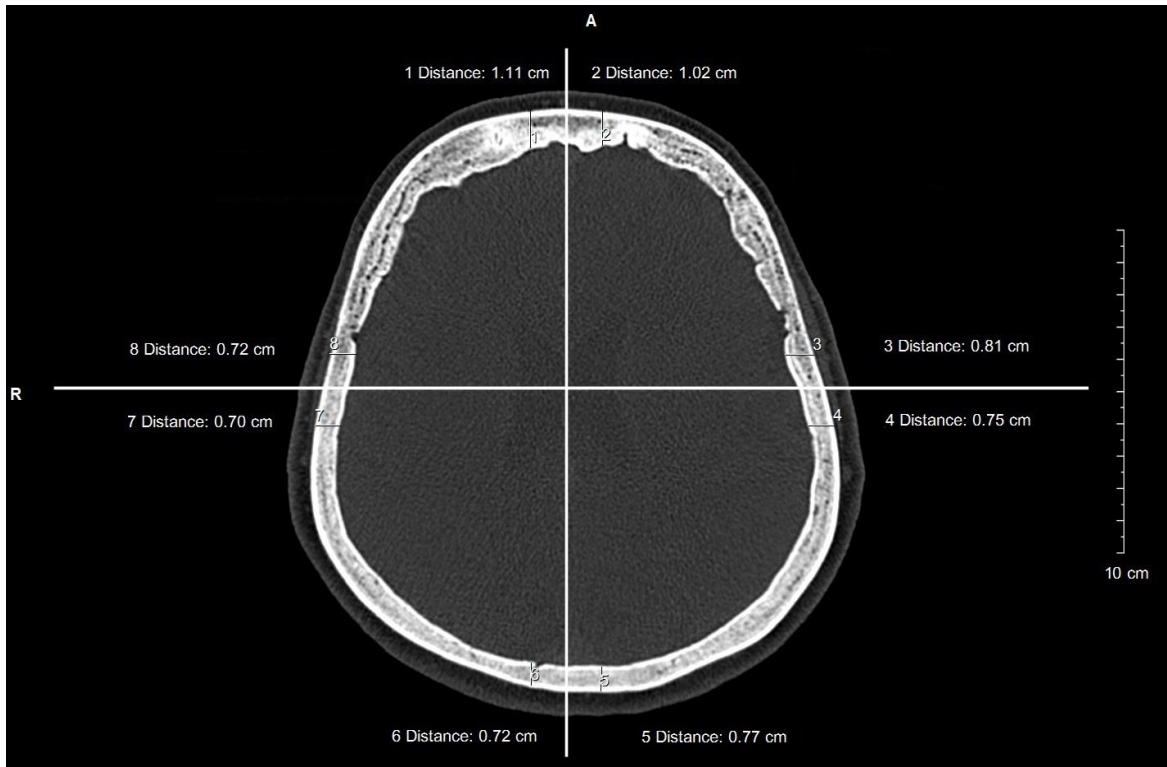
Measurement of the cranial bones thickness on the transversal CT scan of the head: frontal and occipital bone thickness (measured 1 cm lateral to the mid-sagittal axes, perpendicular to the endocranial table surface) and left and right parietal bones thickness (measured 1cm anterior and posterior to the mid-transversal axes, perpendicular to the endocranial table surface).
